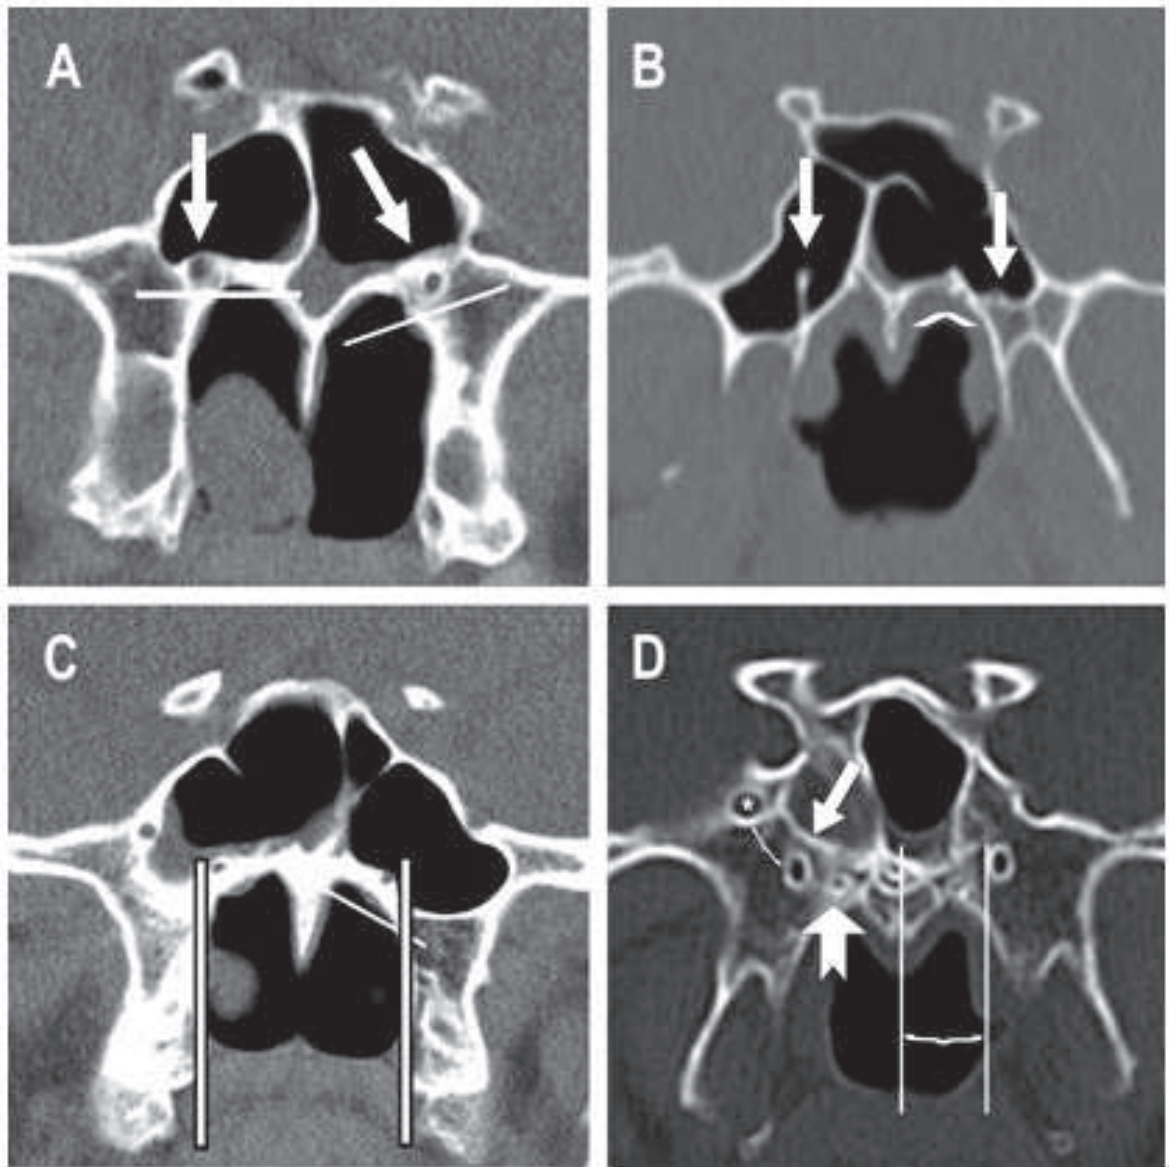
Coronal computed tomography sections showing the vidian canal and its different positions. A, The vidian canal is embedded in the bone (left). Canal floor type 1 (right) and type 2 (left) are shown. B, Complete (right) and partial protrusion (left) into the sinus. Canal floor type 4 with canal wall dehiscence (left) is shown. C, The vidian canal is medially located close to the medial lamina of the pterygoid process (bilateral). Canal floor type 3 (left) is shown. D, Caliper measurement of the distance between the vidian canal and the vomerine crest (left) and between the vidian canal and the foramen rotundum (right; asterisk). Arrows indicate vidian canal; straight lines in A, C, and D and the caret in B indicate the canal-floor relationships. The bifid tail arrow in D indicates the palatovaginal canal.
